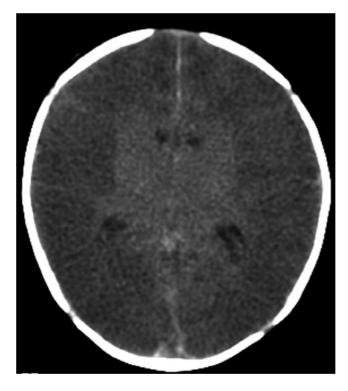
Patient #11. Axial CT shows global low attenuating in the cerebral cortex and subcortical white matter, with sparing of central grey matter. The findings are typical of hypoxic-ischaemic encephalopathy
